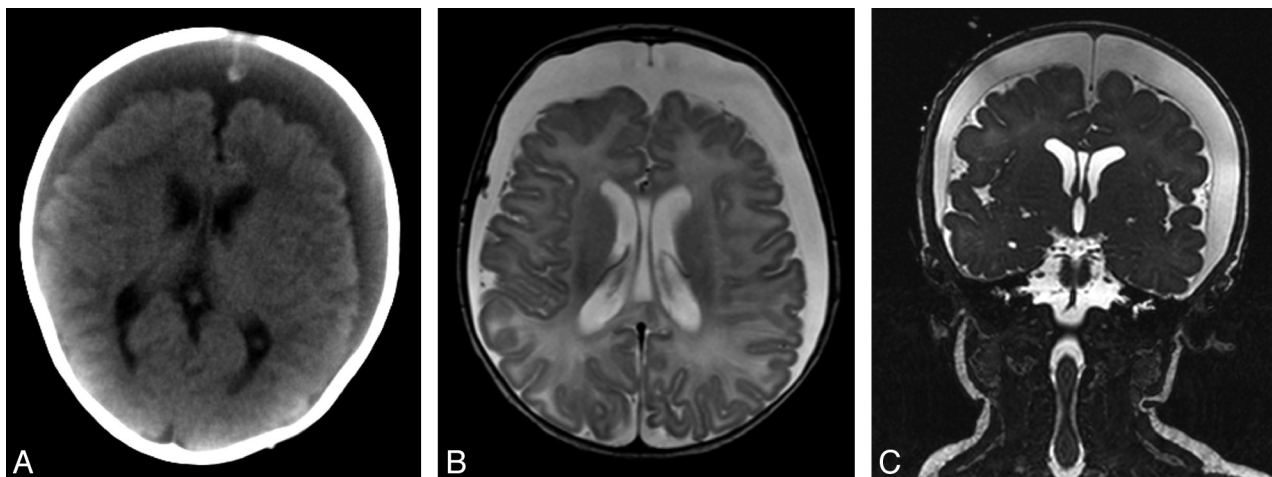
Two-month-old boy with huge hypodense, CSF-like, subdural collections lacking encapsulating membranes (A, cranial CT). MR imaging confirmed the diagnosis of frontoparietal SDHys on both sides (B, axial T2-weighted image; C, coronal T2-weighted image).
